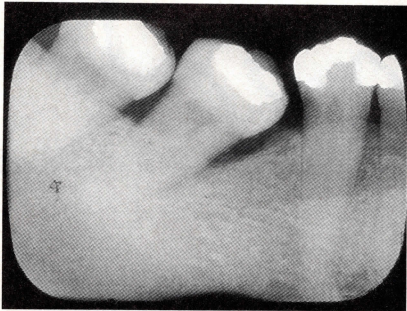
Radiograph of a mandibular right quadrant with long-standing partial edentulism (missing first molar), showing mesial tipping of the remaining molars, loss of potential pontic space, and the formation of an angular crest on the mesial of the second molar.
